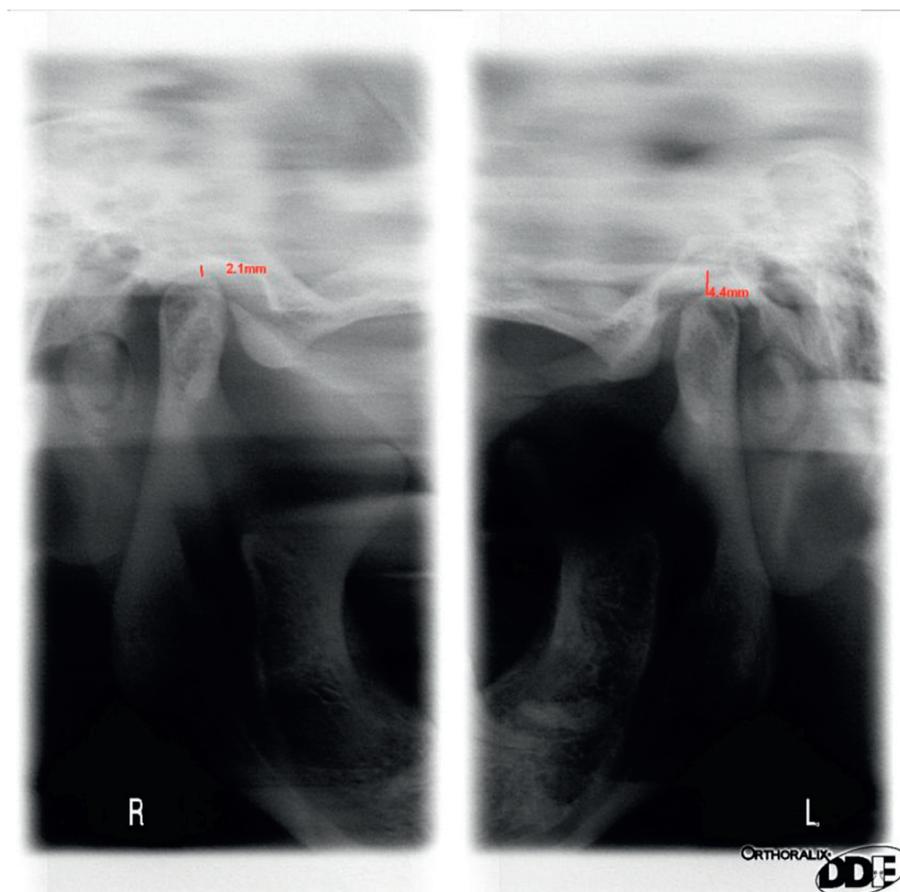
The radiographs of the TMJ and nonconcentric condylar position: in occlusion deficient vertical dimension in the right TMJ (no gap between condyle and fossa in the right TMJ, narrowed joint space).
